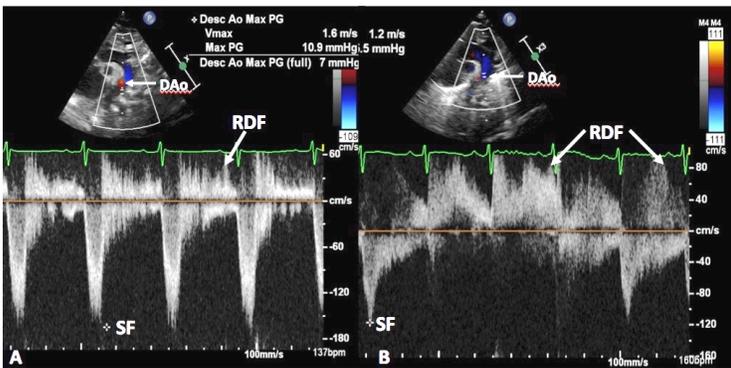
Doppler recordings from a suprasternal notch view demonstrating retrograde diastolic flow (RDF) in the descending aorta (DAo) in two different premature babies (A & B respectively) with large PDA indicating that there is likely to be hemodynamically significant PDA. Systolic flow (SF) (\*) suggests no evidence for obstruction.
